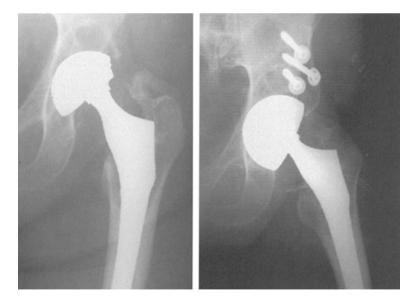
An image that can be detected easily using DL of polyethylene wear on a radiograph [26]
